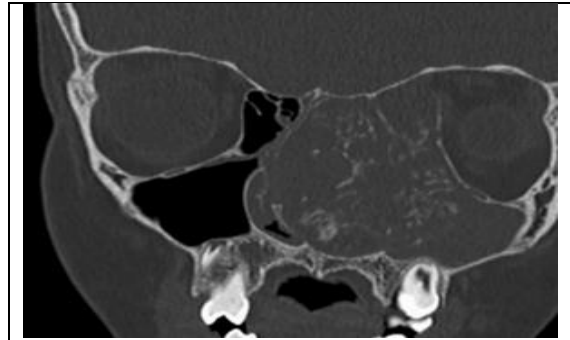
An expansive, calcified intranasal tumor discovered during a sinus CT scan.
